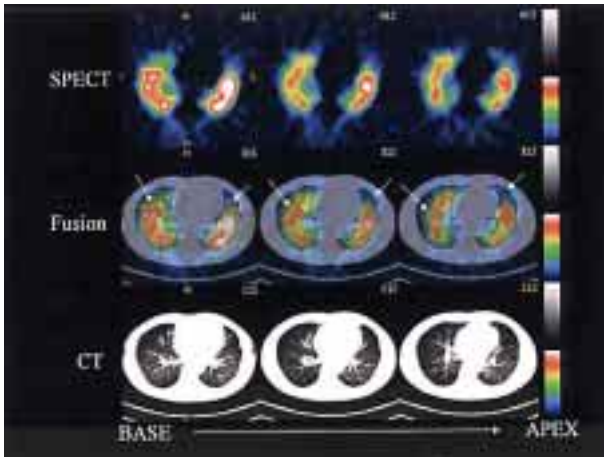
The consecutive fusion images between the respiration-gated inspiration phase Technegas SPECT image and the tidal inspiration CT image, created by a fully automatic image registration algorithm, in a 41-year-old patient with diffuse panbronchiolitis. The fusion images show heterogeneously-reduced Technegas distribution in both lungs, especially corresponding to the relatively low attenuation lung areas on chest CT scan (arrows).
